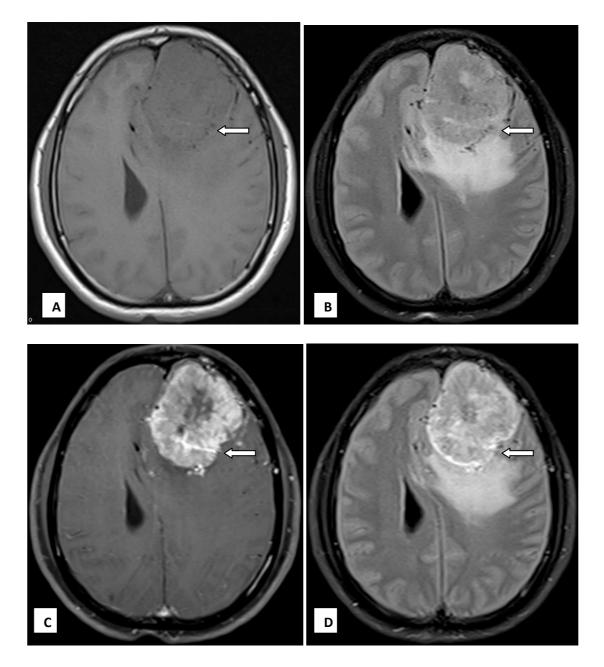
MRI Brain axial sections of 42 year old male diagnosed with meningioma in right frontal region showing a well-defined, T1 isointense (A) & (B) T2 FLAIR heterogeneously hyperintense lesion demonstrating heterogeneous enhancement of lesion which is better depicted on (C) T1 FS PC than (D) T2 FLAIR PC images. The central necrotic component is also better demonstrated in the T1 FS PC images.
